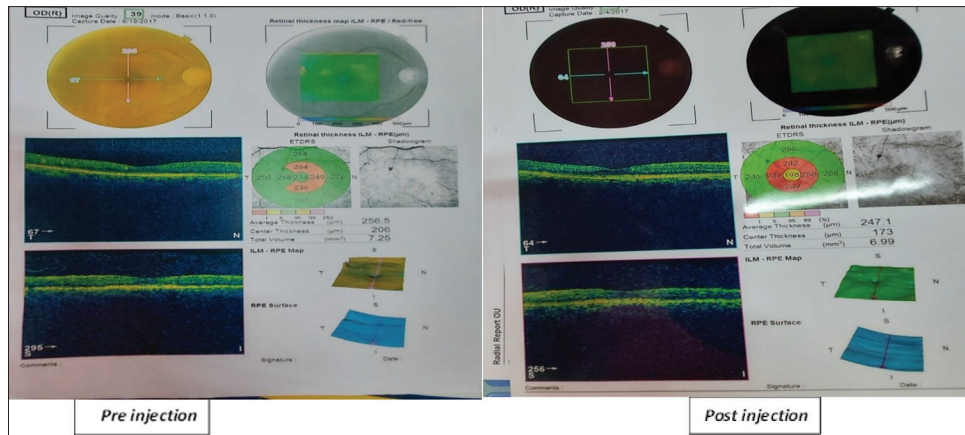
CT of preinjection and postinjection case no. 4. OCT, optical coherence tomography.
